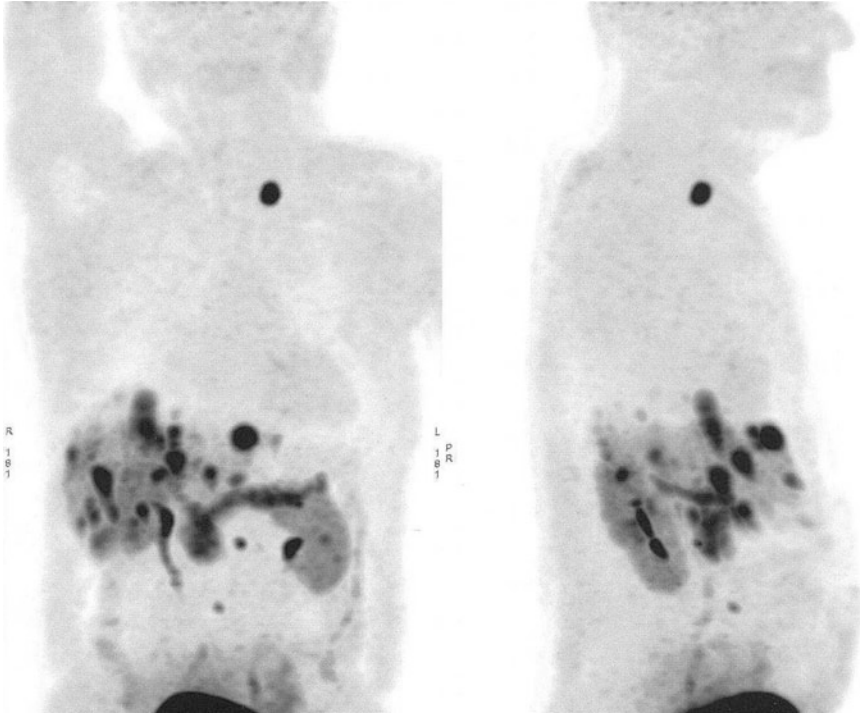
Patient with well-differentiated neuroendocrine tumors: ^{18}F DOPA PET-CT showed multiple liver metastases and sus-clavicular left lymph node
